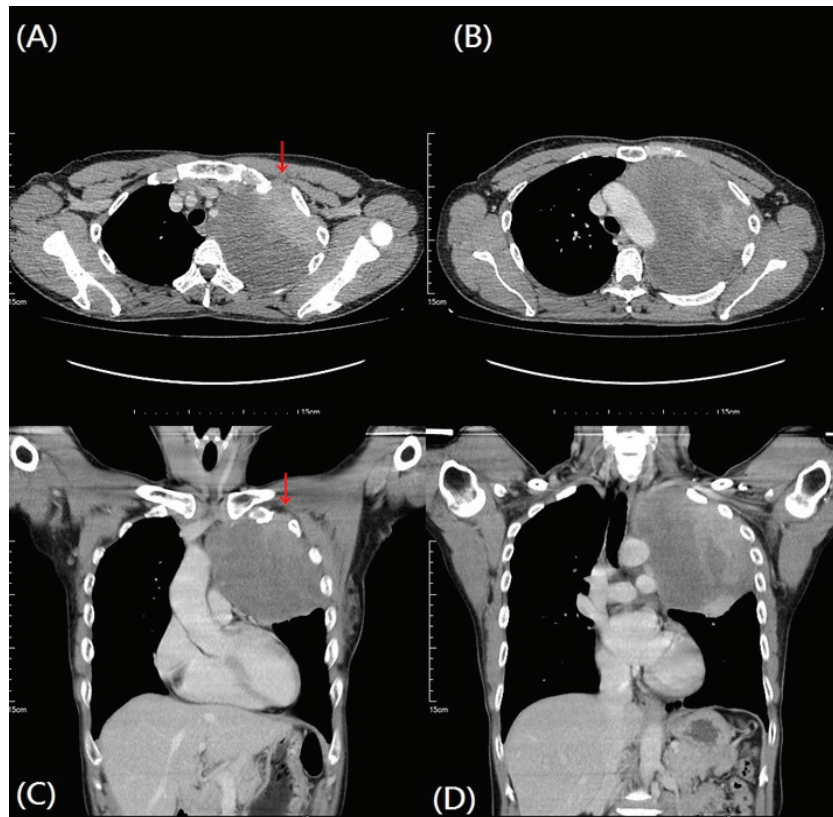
A CT scan of the thorax with contrast, (A)(B) axial view and (C)(D) coronal view, showing an inhomogeneous soft tissue density mass, about 17 cm x 15 cm x 9 cm in size, in the left thoracic cavity, with close contact with the mediastinum and left upper lung, but no obvious vessel or rib invasion. The red arrow shows that the tumor invaded the 1st intercostal muscle.
